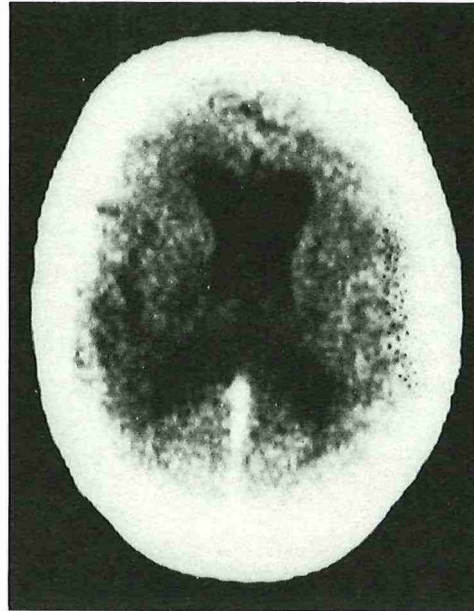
Some metastases have disappeared altogether, some are less conspicuous after high dose VP 16-213 on CT scan of patient no. 1.
